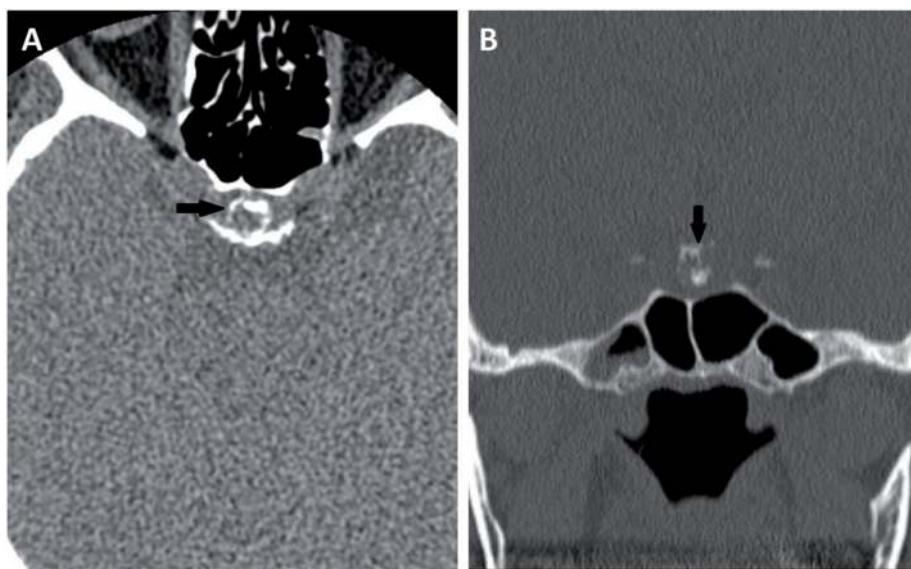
Axial (A) and coronal (B) non-enhanced CT shows suprasellar dispersed calcifications (black arrow) in a patient with adamantinomatous craniopharyngioma.
